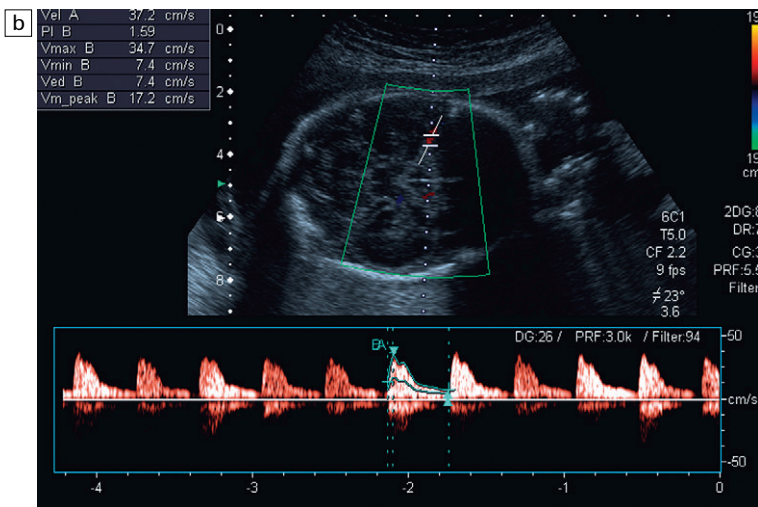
(a) Colour flow Doppler of the circle of Willis in the fetus. The middle cerebral arteries are demonstrated. (b) Spectral flow within the normal middle cerebral artery. Pulsatility index of 1.6 and a peak velocity of 37 cm s⁻¹. (c) Fetal anaemia increase in peak systolic flow velocity to 72 cm s⁻¹ is demonstrated.
